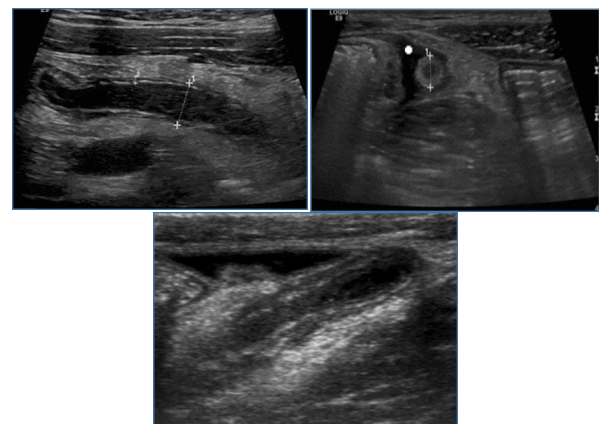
(A) shows longitudinal (B) shows transverse scan of acute appendicitis detected by US (C) shows abdomen ultrasonography
